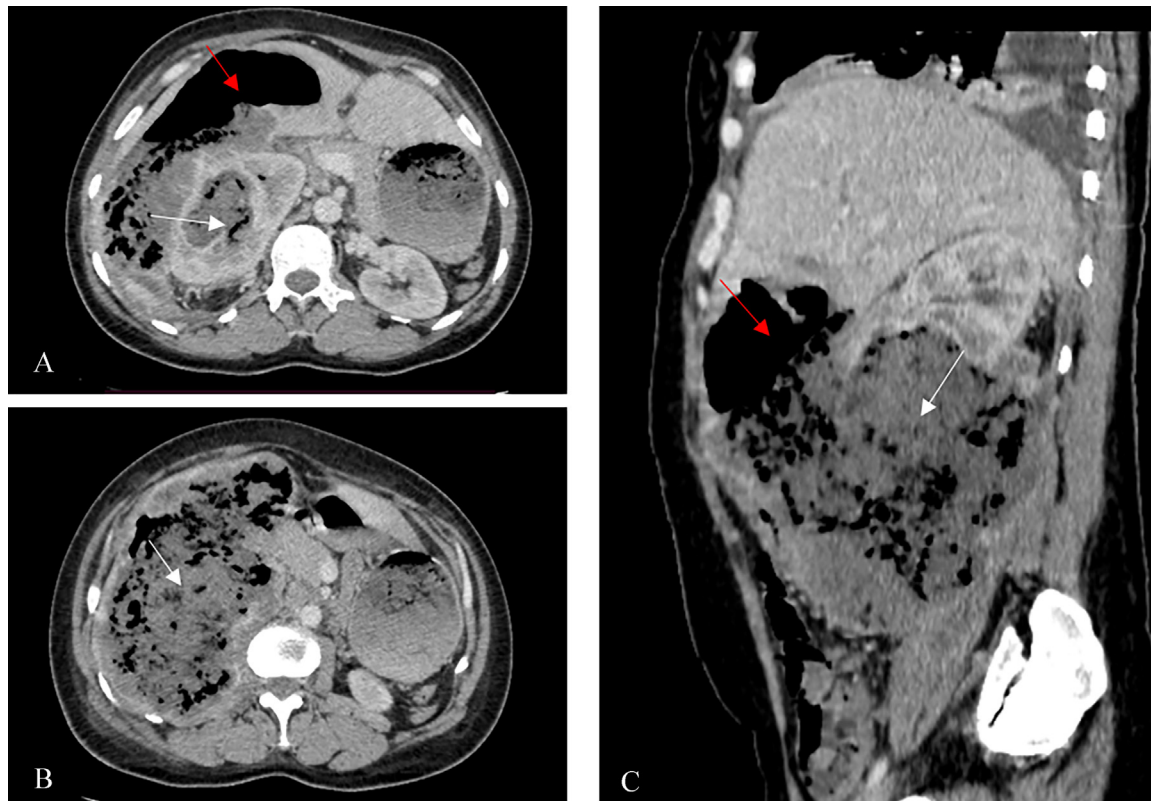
Right emphysematous pyelonephritis with pneumoperitoneum. Axial CT scan (A and B) and sagittal reconstructions (C) showing an enlarged right heterogeneous kidney with parenchymal destruction associated to multiple areas of air density (Red arrow), extending in perihepatic space (White arrow).
